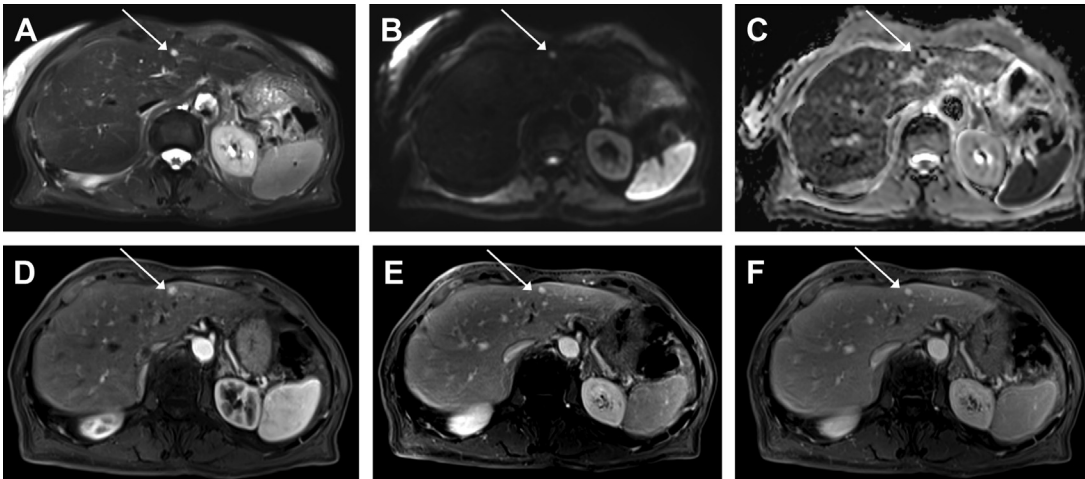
Rapidly filling hemangioma. As a typical hemangioma, the lesion demonstrated marked hyperintensity on T2-weighted fat-saturated images (A), with slight hyperintensity on diffusion (B) without restriction (C). On the postcontrast sequences, enhancement was similar to that of the aorta in the arterial (D), portal venous (E), and delayed (F) phases, with perilesional transient hyperenhancement in the arterial phase.
